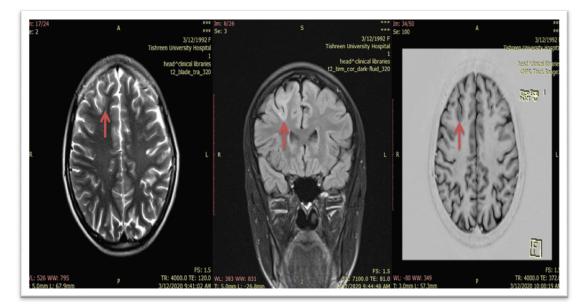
A 28-year-old female was clinically diagnosed with focal-onset seizure. T2WI in axial plane, FLAIR with coronal oblique plane, and 3D acquisition isotropic IR. There is a region of high T2 signal associated with blurring of the grey white matter junction is seen on the right (red arrow), suggestive of right focal cortical dysplasia
